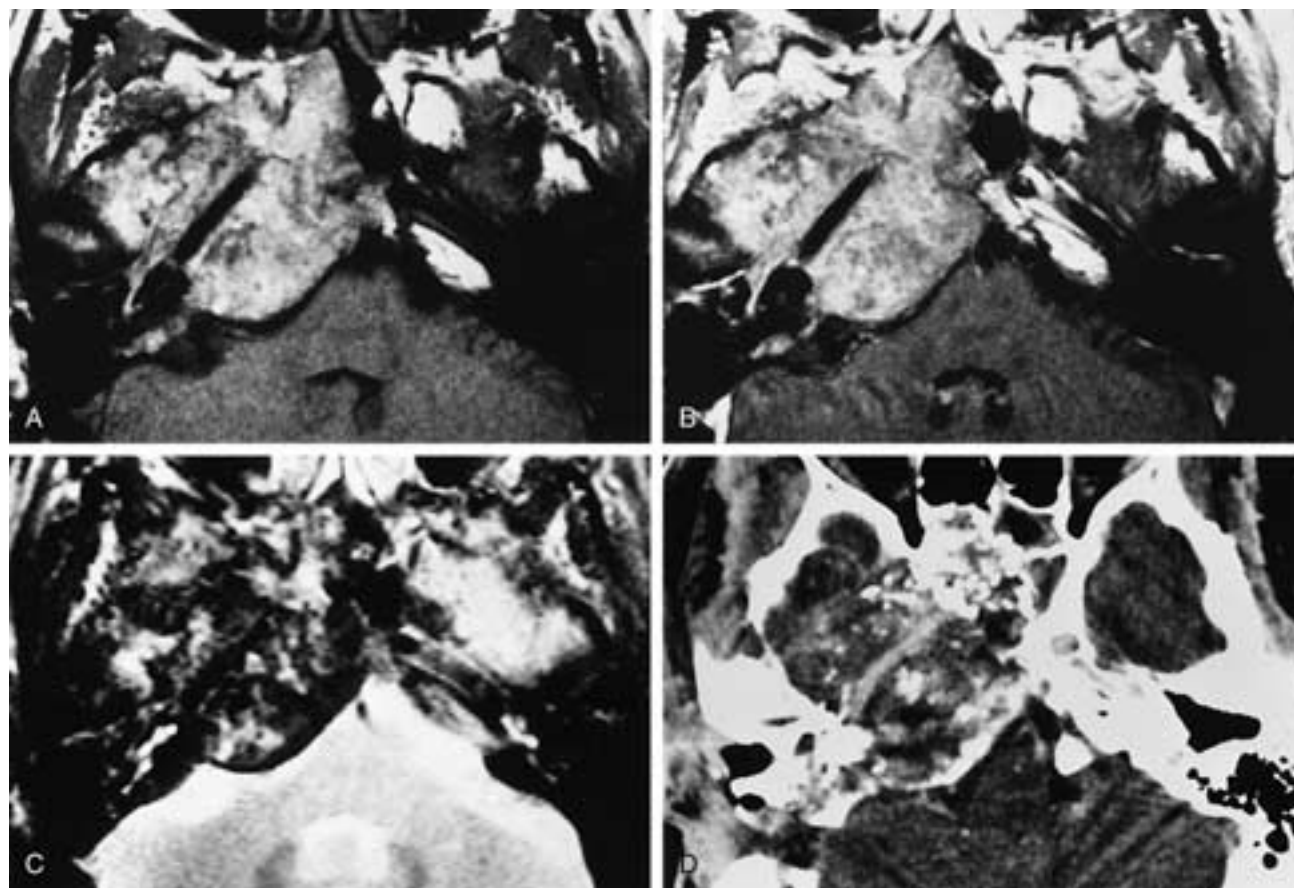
Xanthoma of the right petrous bone. A, T1-weighted image shows heterogeneous moderate hyperintensity. B, Gadolinium T1-weighted image shows no enhancement of the tumor. C, T2-weighted image shows marked heterogeneity of tumor intensity. The tumor could have been mistaken for a chondrosarcoma (see Fig. 25-86) on B and C. D, Postcontrast CT shows many small bony or calcific foci in a completely nonenhancing tumor. Note the enhancing horizontal intrapetrous carotid artery. The CT appearance is also similar to that of a chondrosarcoma except for the lack of enhancement.
